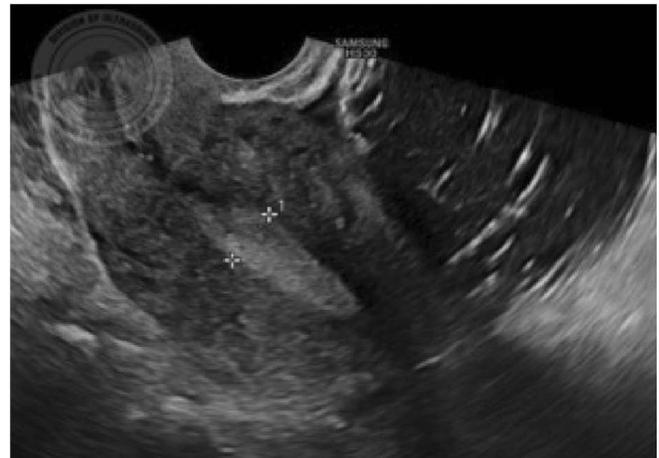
Transvaginal ultrasound demonstrating the mass in relation to the uterus.
